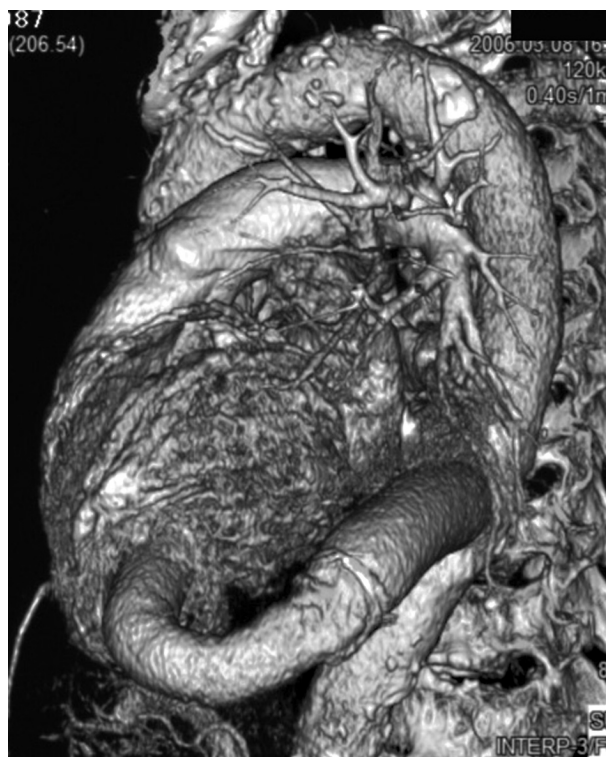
Postoperative computed tomography after AAVC insertion demonstrated unobstructed conduit.
